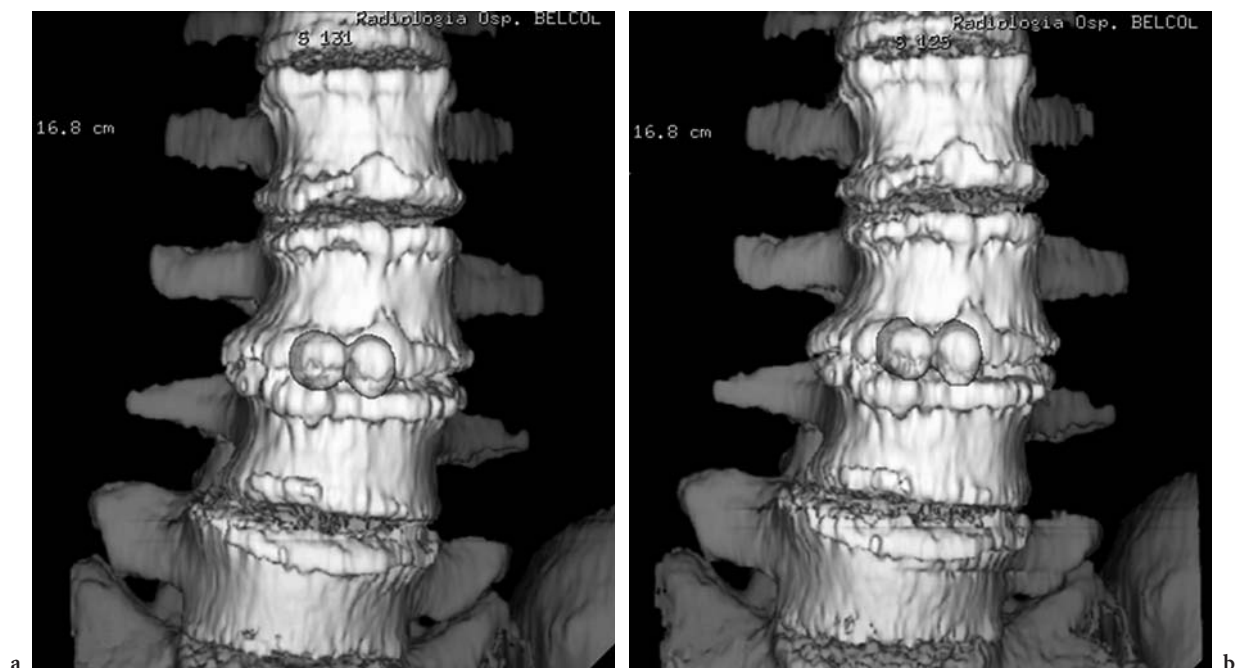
a Basal CT, 3D anterior view. Young male (29 years old) after positioning of four DIAM. Mild left-convex scoliosis. The patient still has low back pain in orthostatism. b AL-CT. Same patient; during loading further left-convex scoliosis, with CCW rotation of L2 and L3 bodies and CW rotation of L4 and L5 bodies. On “Z” axis. Deformation of L3–L4 disc space and anterior reduction of L5–S1 disc space (paradoxical motion). Pain during axial loading. c Basal CT, 3D posterior view. Young male (29 years old) after positioning of four DIAM. Mild left-convex scoliosis. d AL-CT. Same patient; during loading further left-convex scoliosis, with CCW rotation of L2 and L3 bodies and CW rotation of L4 and L5 bodies. On “Z” axis. Minimal superior translation of L5 neural arch (paradoxical motion). It is possible to evaluate the deformation of the interspinous devices due to the work the devices perform during axial loading
